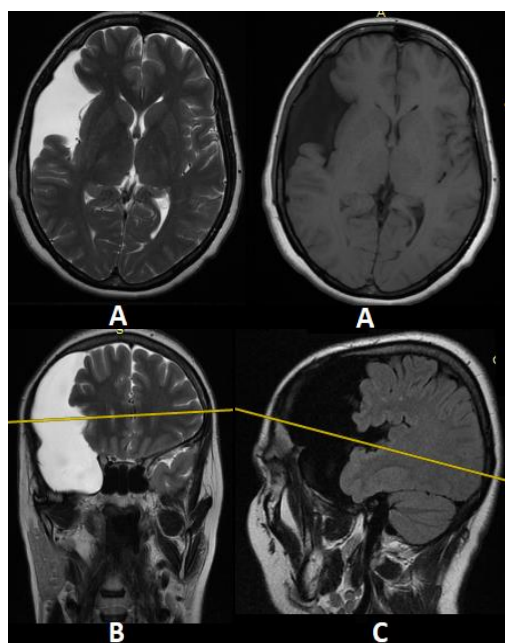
Axial T2, T1(A), coronal T2 (B), and sagittal T1 (C) non-contrast-enhanced magnetic resonance imaging (MRI) indicates a large right
